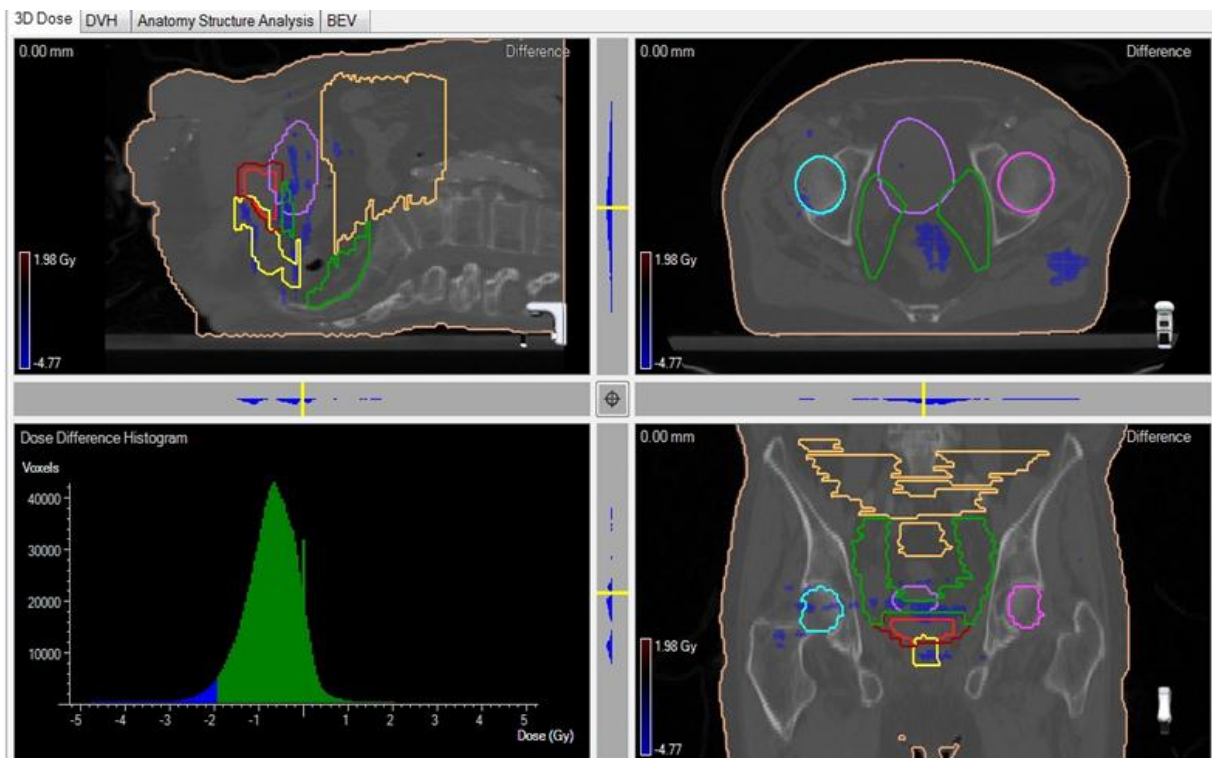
In the 3DVH program the dose difference (blue areas lower and red areas higher) between measured and TPS's fluences are displayed on the CT images of the patient (Patient L), making it possible to analyse the Patient QA in a 3D manner.
